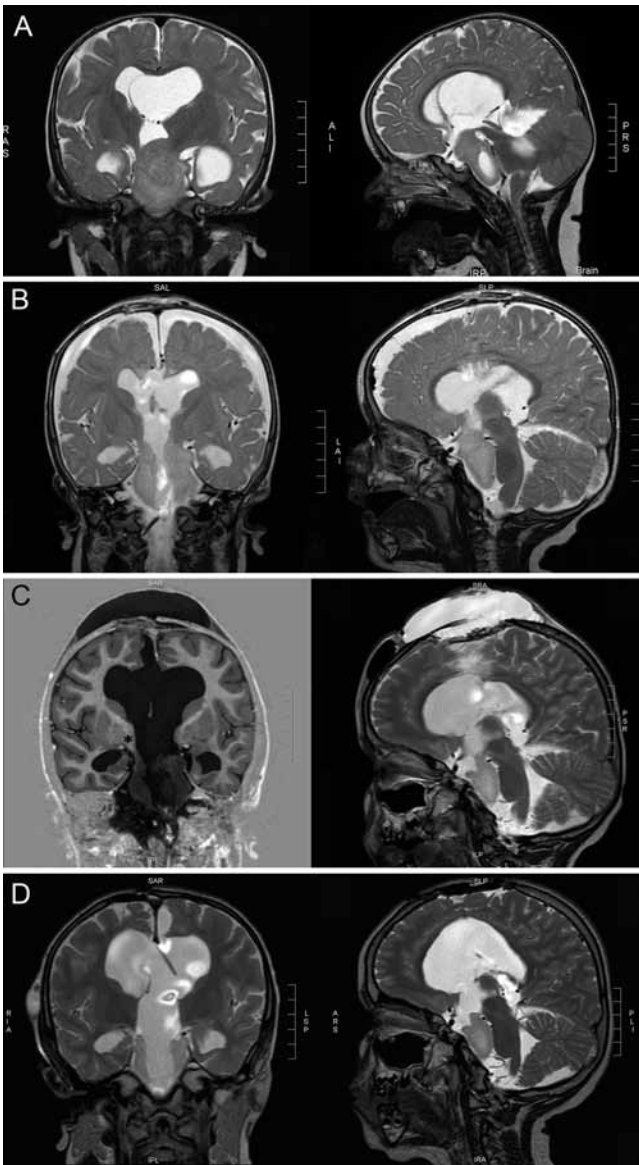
Coronal and sagittal T2-weighted MR images displaying the solid tumor part as mainly isointense to gray matter–appearing mass, located ventrally to the brainstem. A: Images at presentation showing compression of the distal aqueduct by the solid component of the hamartoma anteriorly and the cystic component posteriorly, causing mild hydrocephalus. B: Images obtained after the first partial resection, decompression of the aqueduct, and communication of the cyst through the solid part of the HH to the basal cisterns. C: Images obtained after second surgery demonstrating right posterior parts of the hamartoma still connected to the hypothalamus (*asterisk*). D: Images obtained after third transcallosal operation demonstrated a completed disconnection.
